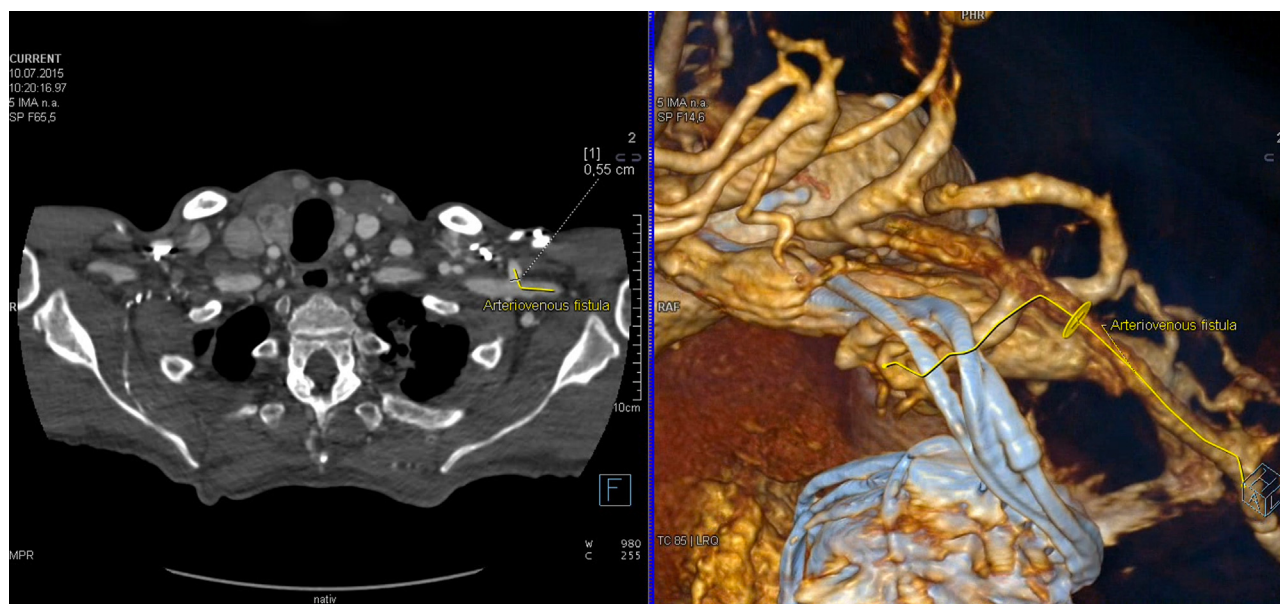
Pre-interventional contrast-enhanced computed tomography (left side) and computed tomography angiography (right side). A yellow line demonstrates the course of the arteriovenous fistula.
